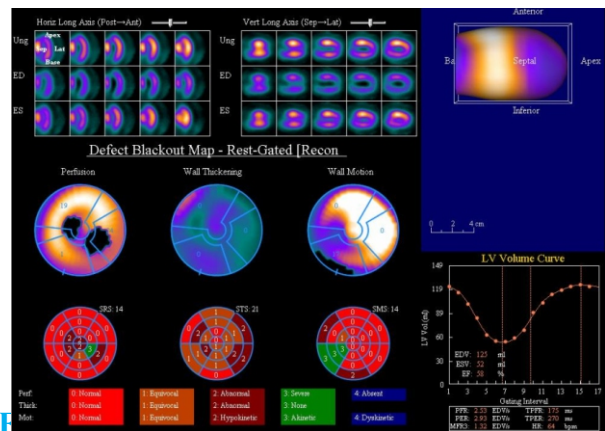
Cedars- Sinai Quantitative Gated SPECT (QGS) program for assessment of LV systolic and diastolic function parameters. QGS uses 16 or 32 frames per cardiac cycle gated SPECT data for assessment of diastolic function variables. Peak ejection rate (PER), peak filling rate (PFR), secondary peak filling rate (PFR2), Mean filling rate over first one third diastole (MFR3) and time to peak filling (TTPF).¹⁹
